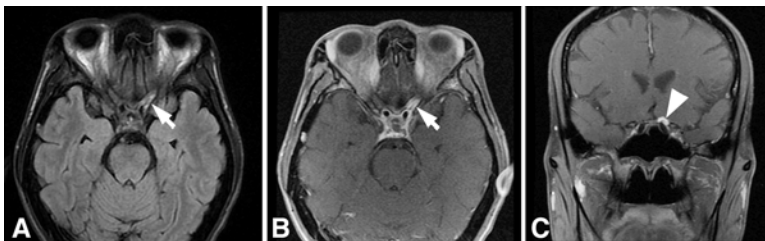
Seven days after loss of vision in the left eye FLAIR (A), and contrast-enhanced T1 axial (B) and coronal (C) MRI demonstrate an enhancing lesion in the suprasellar cistern (arrowhead) with enlargement and enhancement of the adjacent left optic nerve (arrows).
